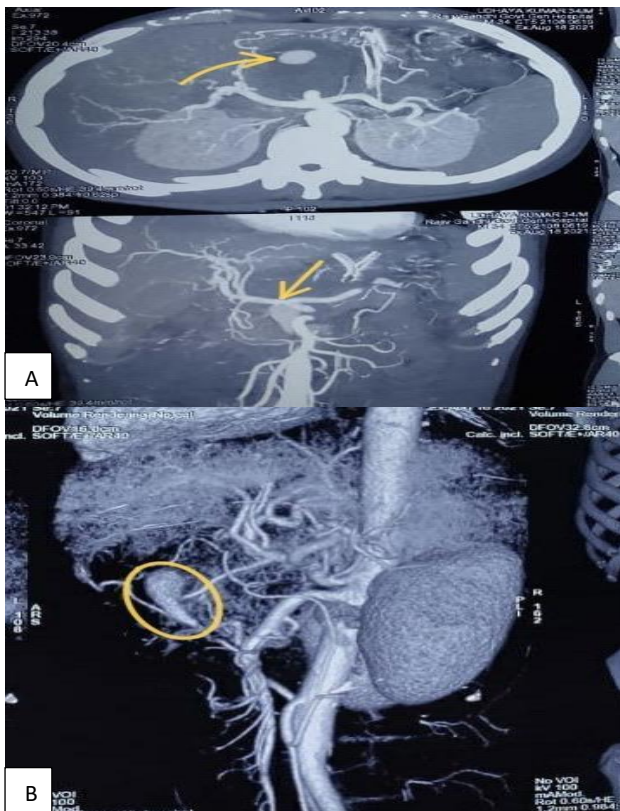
(A and B): CECT abdomen and CT angiogram showing the pseudocyst pancreas with the posterior IPDA (inferior pancreaticoduodenal artery) pseudoaneurysm, as indicated by the arrow and encircled.
